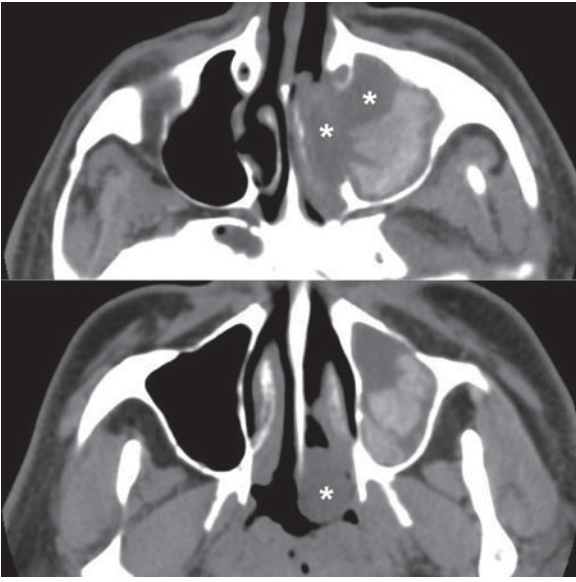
Antrochoanal polyp. Axial CT images show a low-density polyp (*asterisk*) extending from the antrum, across the nasal cavity, through the choana, and into the nasopharynx. Fungal colonization of entrapped secretions results in high density in the remainder of the antrum
